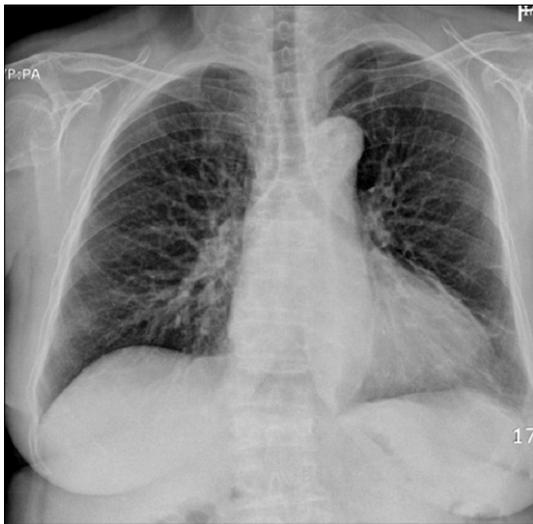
Chest radiograph shows no parenchymal lung lesion before the treatment of adalimumab.
